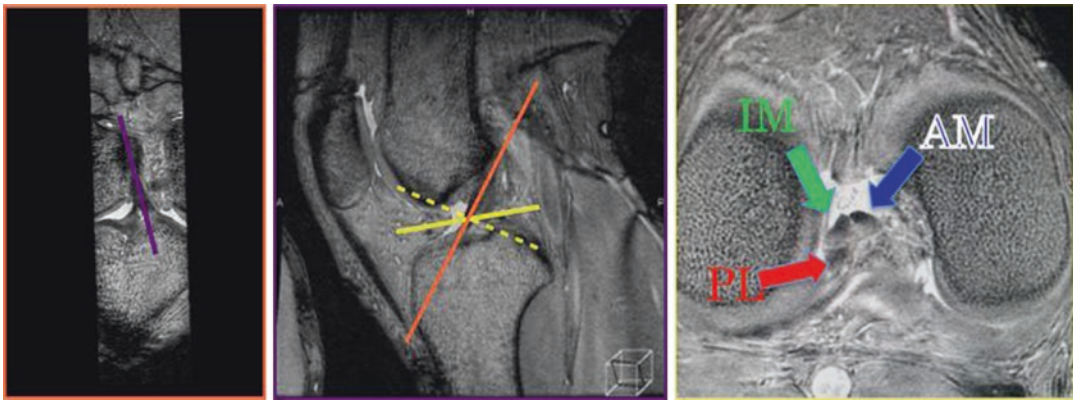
A 36-year-old man was examined using 3D isotropic sagittal MRI with the sequence of Coherent Oscillatory State acquisition for the Manipulation of Image Contrast (COSMIC) with fat suppression. The
